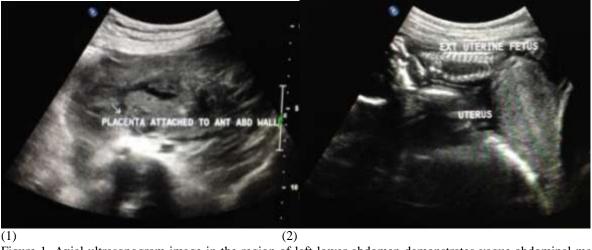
Axial ultrasonogram image in the region of left lower abdomen demonstrates vague abdominal mass with echogenicity similar to placenta, attached to the abdominal wall anteriorly, displacing bowel loops surrounding it.
